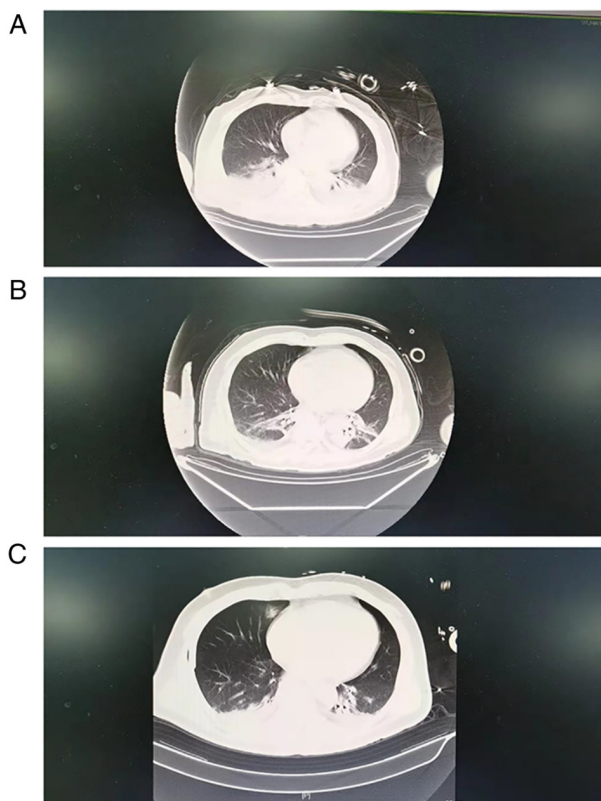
CT scan images of the patient. CT scan images on (A) day 1, (B) day 2 and (C) day 15 of intensive care unit. CT, computed tomography.
